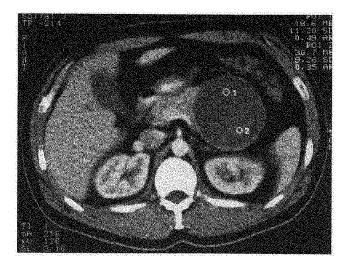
Case 1. CT scan showing cystic tumor in body of pancreas.
